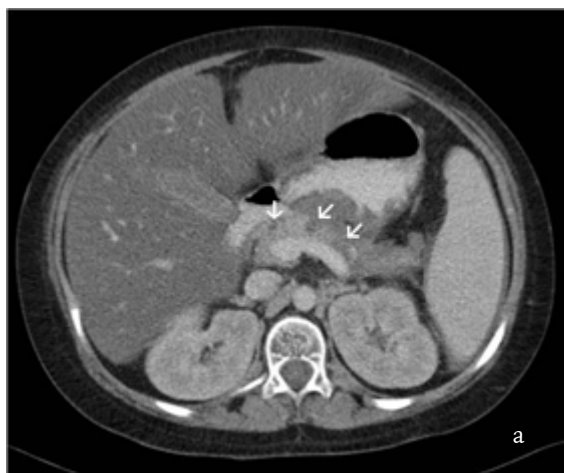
a) CT portal phase images show cystic changes and edema in the pancreatic corpus and tail (white arrows). b) There is prominent soft tissue thickening surrounding the transverse colon (black arrows) and mass appearance at the omentum (black asterisk). Intraperitoneal fluid collections are also present (white arrow).
